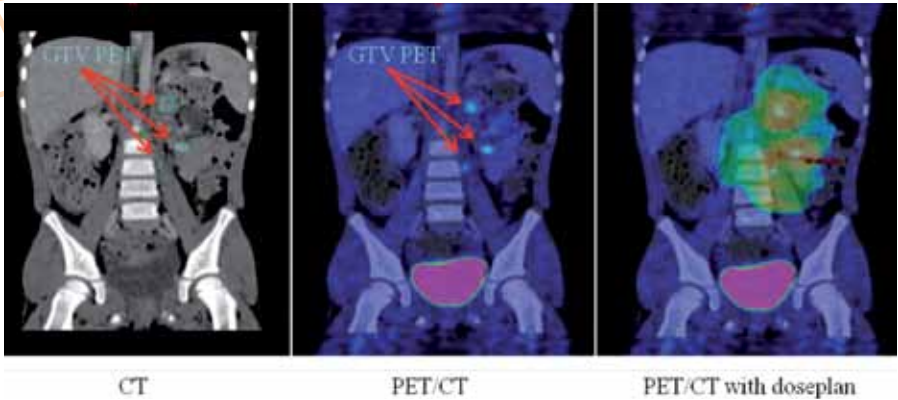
Example of PET/CT-based radiotherapy planning of a paediatric tumour (sarcoma). The identification of the tumour is difficult on the CT scan (left), while PET shows a few FDG-avid regions in the abdomen (delineated using a blue curve). These regions, and a margin deemed sufficient, are included in the subsequent radiation therapy plan showing the dose distribution in temperature scale/colourwash (right).
